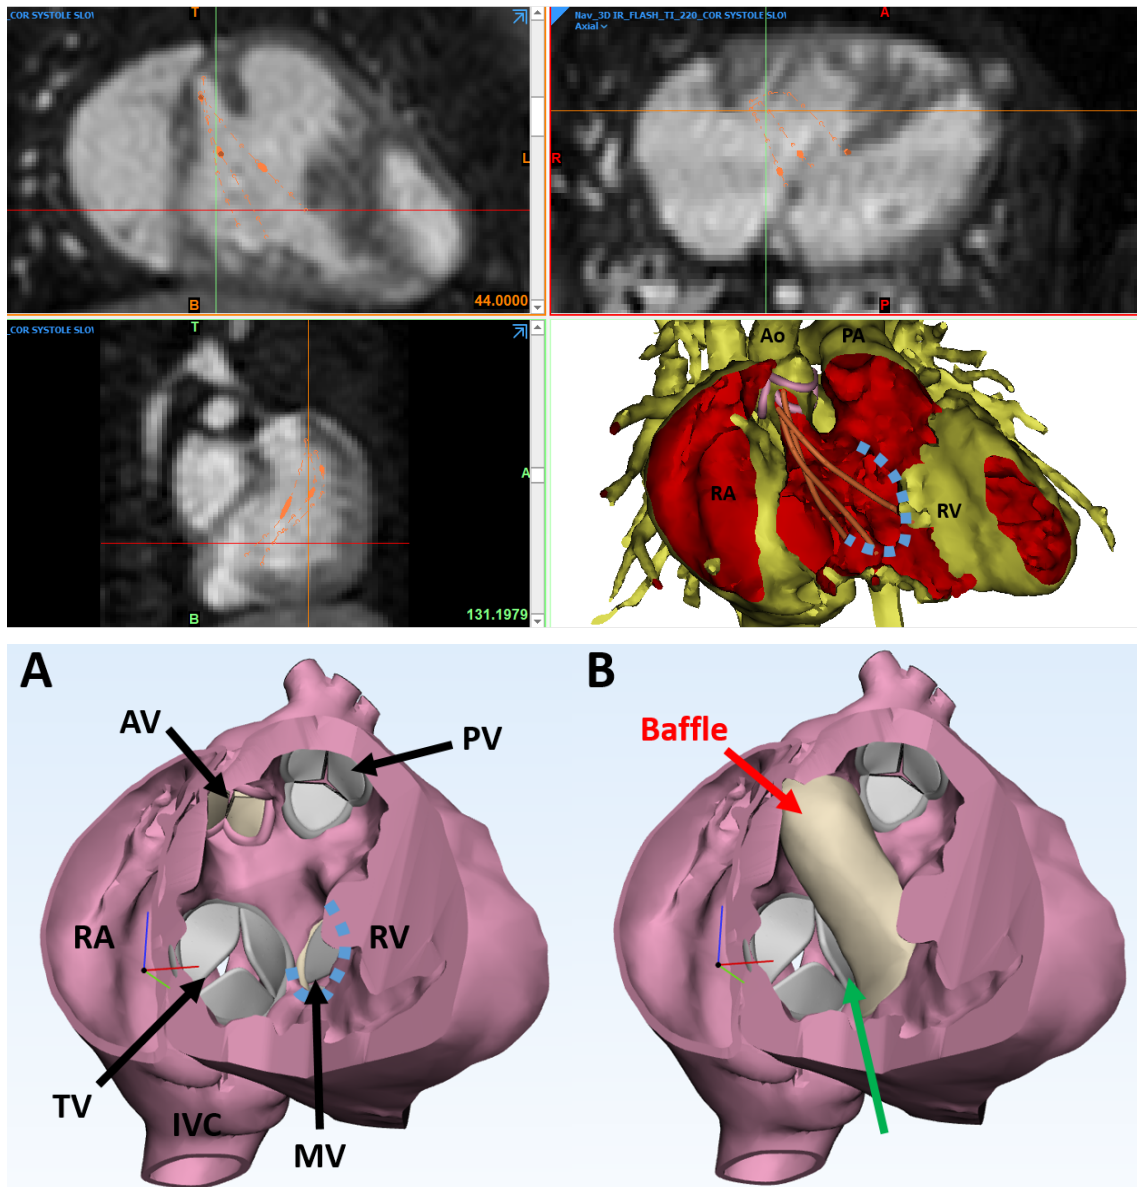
Graphically-design intraventricular baffle to assist in pre-surgical decision making in a double outlet right ventricle (DORV) case. Top/middle panels: A spline tool is used to trace the ideal curvature of the baffle from the ventricular septal defect (VSD) rim (blue-dashed line) to the aortic valve on a patient computed-tomography (CT) images (orange lines). A: Septal model with myocardium following resection of infundibular septum. The right ventricular (RV) wall is removed to assist with the view. All the valves are graphically-designed and included in the model. B: The graphically-designed baffle is added to the model, based on the pre-drawn lines on the CT images. The surgeon is able to evaluate the length of the baffle and how much of the RV cavity it will occupy and the proximity to tricuspid valve (TV) [green arrow]. (Ao = aorta, AV = aortic valve, IVC = inferior vena cava)
